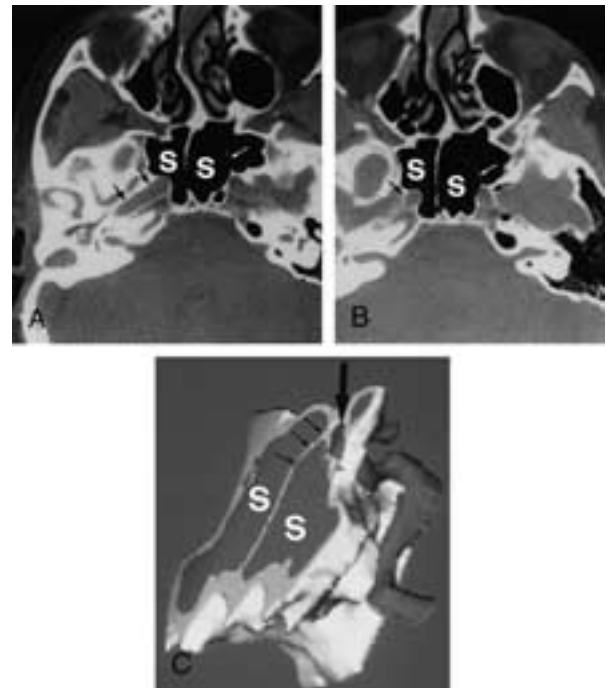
Relationship of the carotid canal to the sphenoid sinus. A and B, Axial CT images through the sphenoid and ethmoid sinuses show that the carotid canals (*small black arrows*) penetrate into the sphenoid sinus (*S*). An incomplete sphenoid sinus septum (*white arrow*) connects to the bony covering of the carotid canal. C, Three-dimensional images of the sphenoid sinus (*S*) and presellar and juxtasellar portions of the internal carotid artery (*black arrow*) graphically display the close relationship between the internal carotid artery and the sphenoid sinus septation (*small black arrows*).
